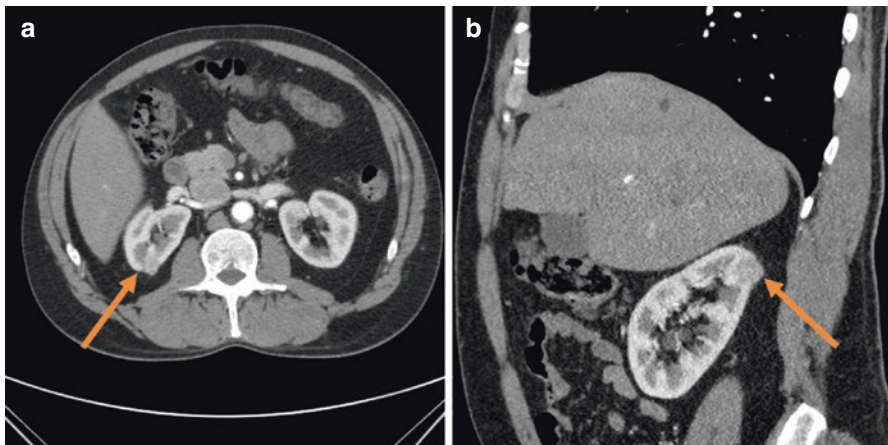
(a) axial and (b) coronal computed tomography images of a “simple-complexity” lesion. R.E.N.A.L nephrometry score = $1 + 2 + 1 + p + 1 = 5p$
